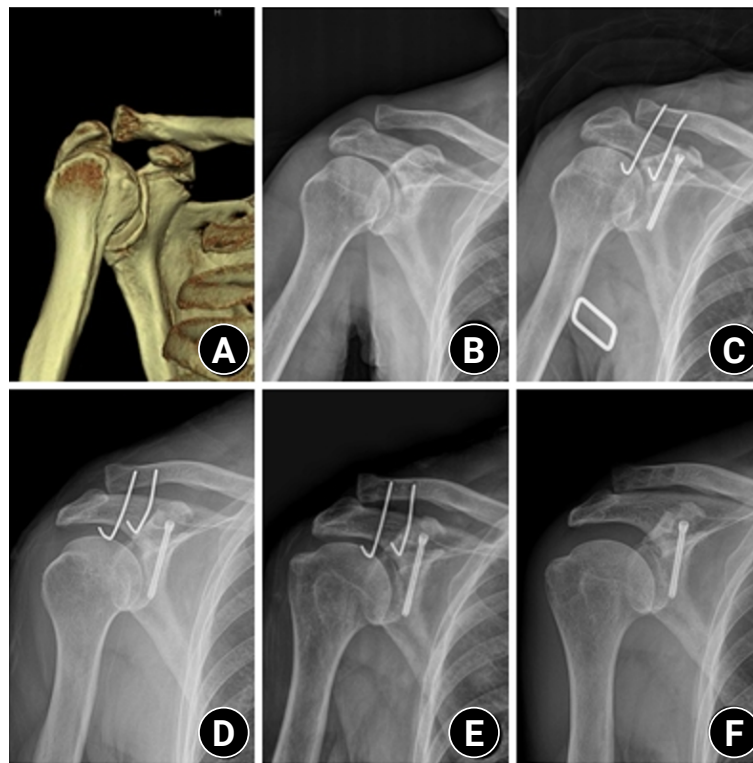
Three-dimensional computed tomography (A) and shoulder anteroposterior (AP) radiograph (B) of a 74-year-old male patient show a coracoid process fracture associated with an acromioclavicular joint (ACJ) injury. (C) A 3.0-mm headless compression screw was used for the coracoid process fracture, and two Kirschner (K)-wires were used for the ACJ injury. (D) Postoperative 2-week radiographs show K-wire deformation. (E) Postoperative 6-week radiographs show K-wire loosening. (F) Postoperative 6-month AP radiographs show non-union of the coracoid process.
